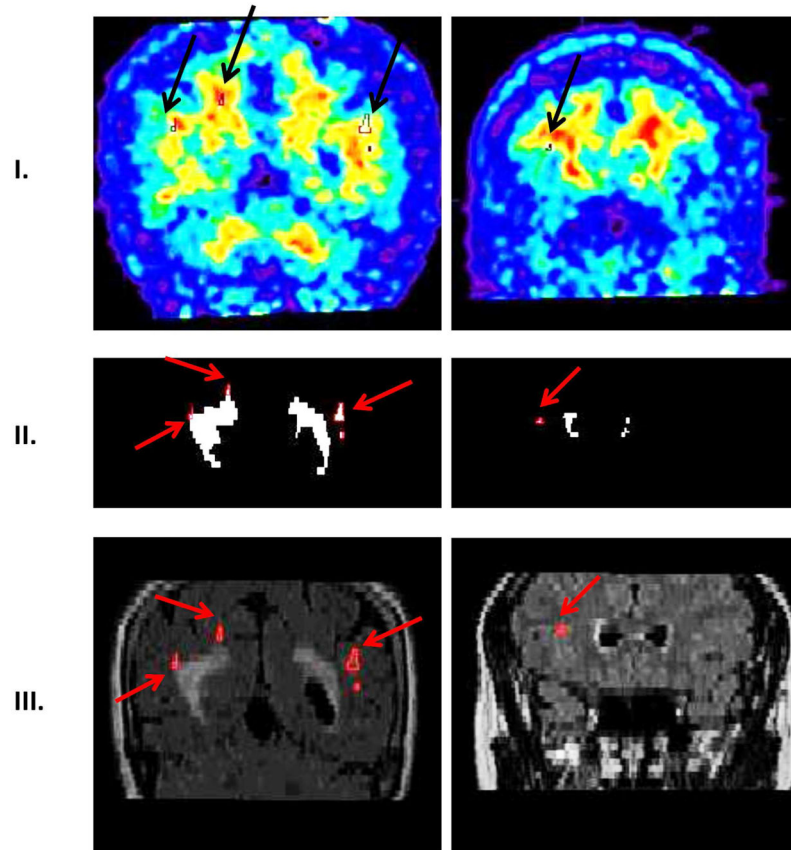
Separation of deep WML (DWML) from the WML mask. Row I shows PiB images (DWML outlined in black with black arrows). Row II shows WML mask (DWML outlined in red with red arrows). Row III shows FLAIR images (DWML outlined in red with red arrows). First column represents case presented in Figure 1A, second column case presented in Figure 1B.
